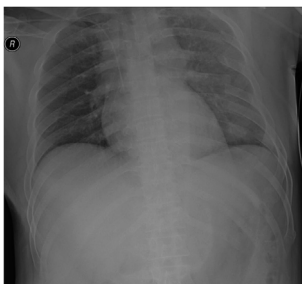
Initial chest radiograph showing displaced fractures of the left fifth to eighth ribs with paradoxical movement and hemothorax.
